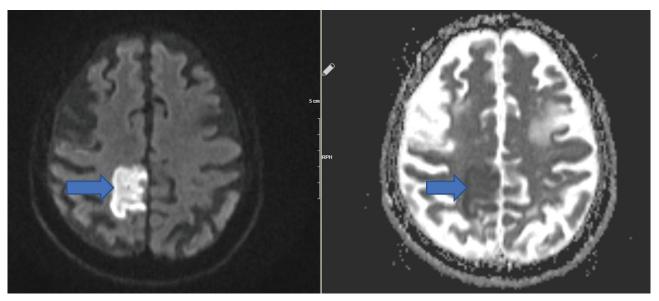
Acute infarct located paramedian at the vertex level in the right frontoparietal vertex in diffusion MRI imaging, involving cortical-subcortical areas, and its counterpart in ADC sequence.
